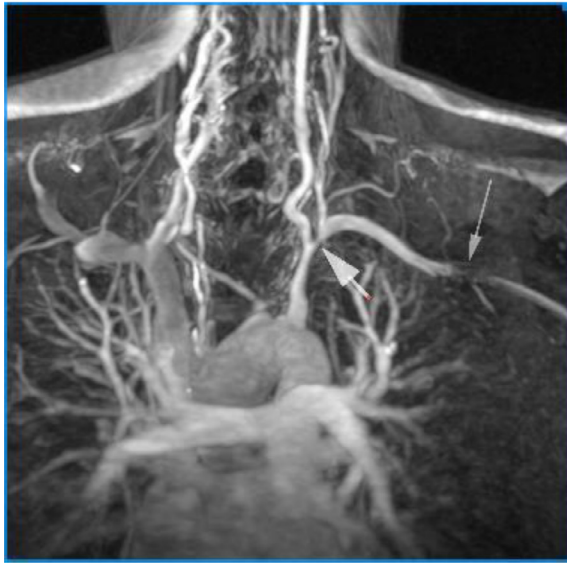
Angio MRI thoracic aorta presenting: 2 stenoses at the left subclavian artery (proximally around the origin of the left vertebral artery (thick arrows) and distally at the junction of the left axillary artery (arrowhead). In addition, diffuse narrowing of the brachiocephalic trunk that continues with the right subclavian artery, without giving off the totally occluded right common carotid artery is noted (thin arrows). Ostium of the right vertebral artery is stenotic. Neck MRA shows bilateral occlusion of the common carotid arteries, which fill with contrast via collaterals at their carotid bifurcation levels (arrows). Filling of the cervical internal carotid artery is still not satisfactory on the right side.
